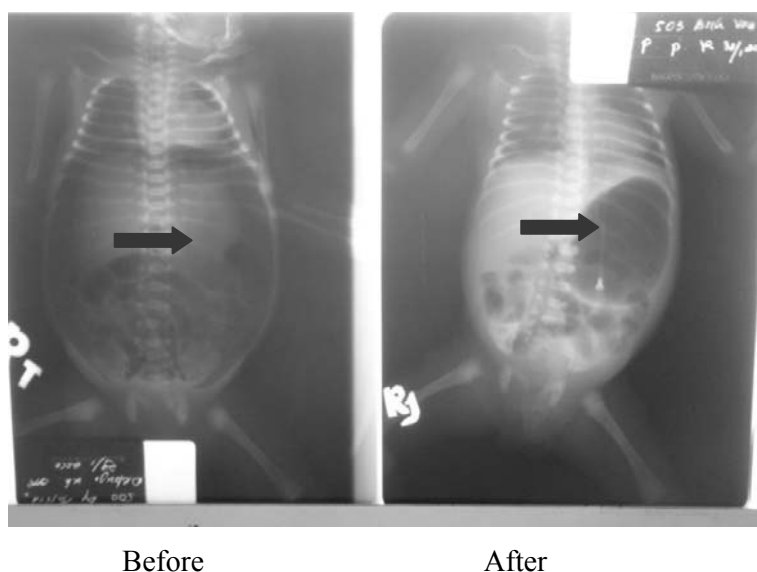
Abdomen plain x-ray before and after needle aspiration.
